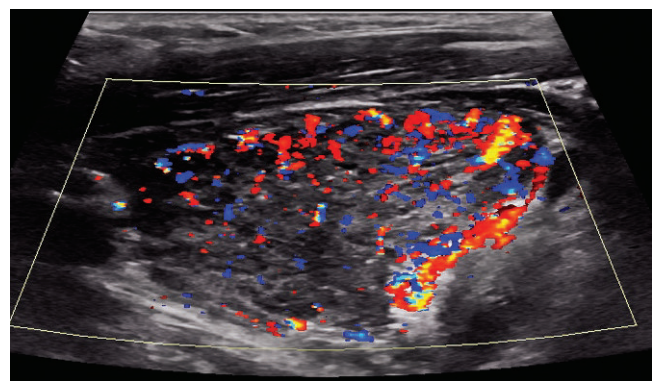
The longitudinal color Doppler image of the right lobe of the thyroid shows hypervascularity.
